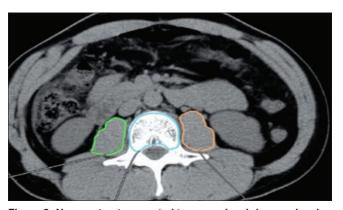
Non-contrast computed tomography abdomen showing psoas muscle cross-sectional area at the level of L3 vertebra
